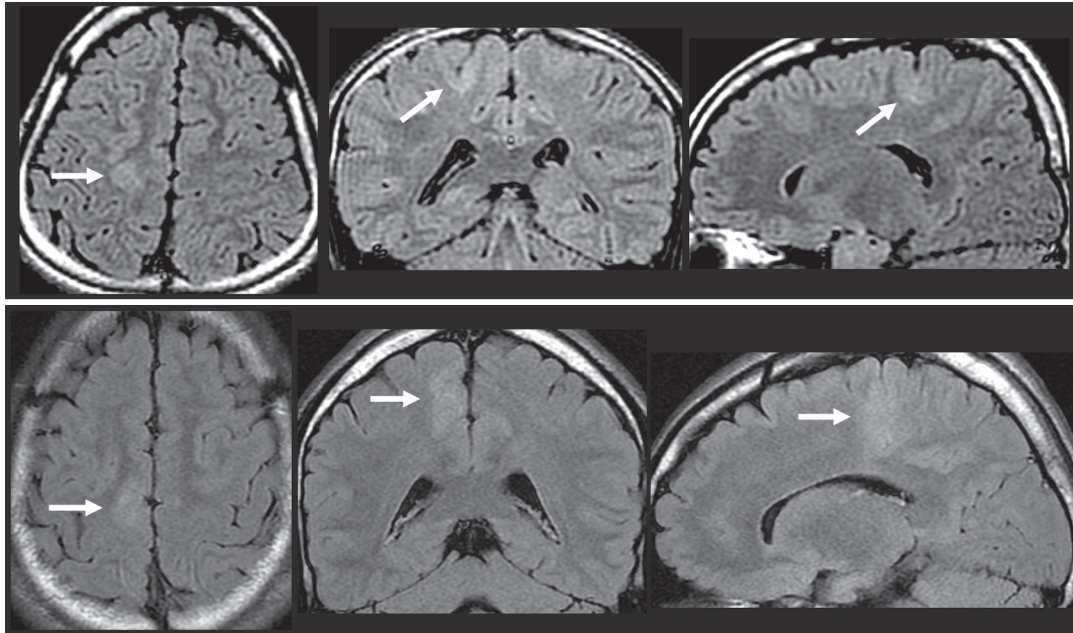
Fluid attenuation inversion recovery-magnetic resonance imaging of two patients with perirolandic focal cortical dysplasia. White arrows indicate hyperintensity areas which represent the presence of focal cortical dysplasia located mainly in the primary motor area.
